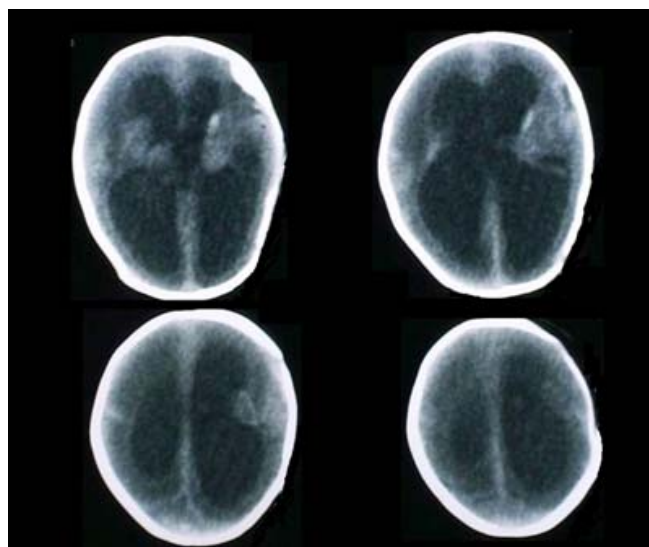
Preoperative brain CT images showing hydrocephalus
